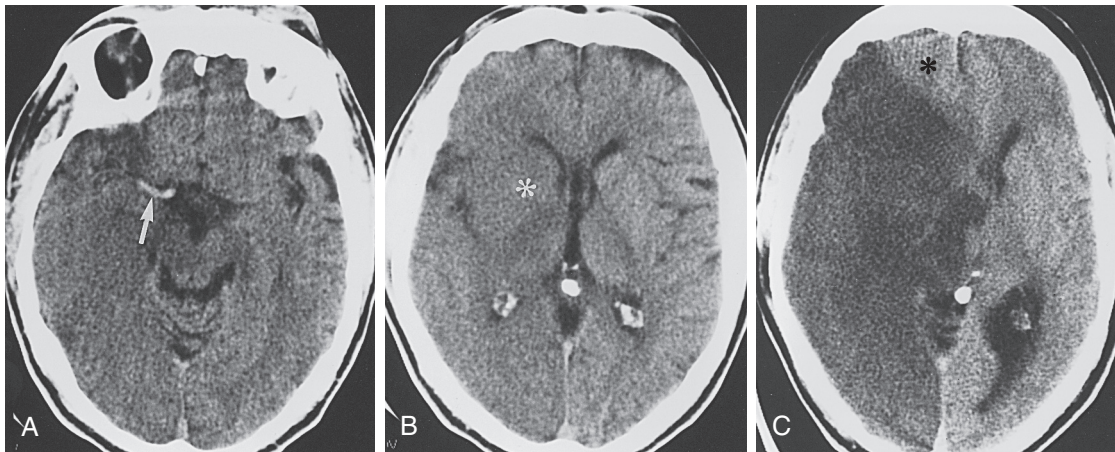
■ Acute infarct. Axial non-contrast-enhanced computed tomography (CT) images obtained at level of temporal lobe (A) and through level of basal ganglia (B) demonstrate area of low density involving gray and white matter of right hemisphere. There is loss of gray-white matter differentiation, especially noticeable in region of basal ganglia (asterisk, B). Compare right and left sides. High density is identified within right middle cerebral artery (arrow, A), representing clot. Axial non-contrast-enhanced CT scan obtained 48 hours later (C) demonstrates marked edema involving territories of right, middle, and posterior cerebral arteries. Note sparing of right anterior cerebral artery territory (asterisk, C).
